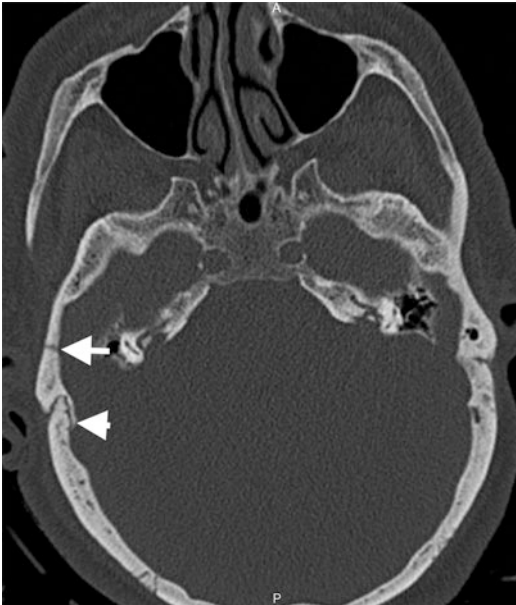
Cranial fracture and suture. Axial CT image at bone window shows a linear fracture in right temporal bone with sharp and non-sclerotic edges (arrow) nearby occipitomastoid suture, which manifests with interdigitating appearance and sclerotic edges (arrowhead)
